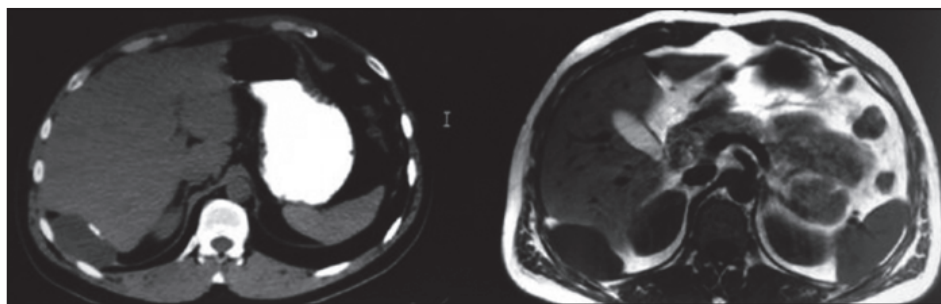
CT scans of the abdomen showing ascites
